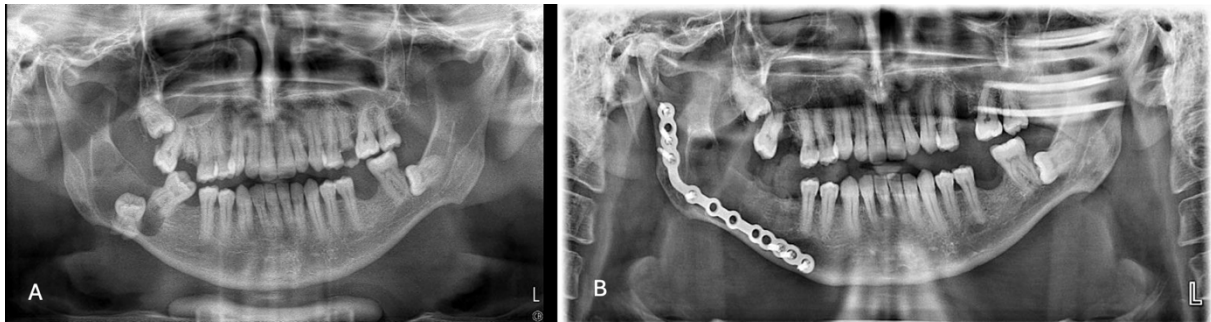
(A) Preoperative panoramic radiograph showing a large mandibular cyst. (B) Postoperative panoramic view following surgical management and reconstruction plate application.
